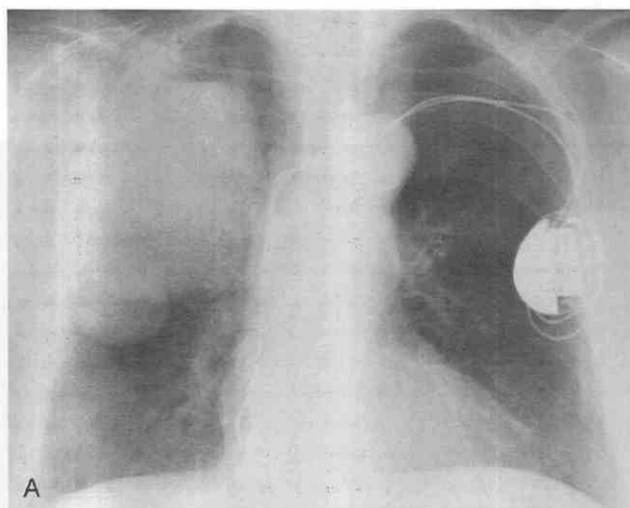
Large-cell lung cancer manifesting as a large cavitory mass. *A*, Posteroanterior chest radiograph shows a large, lobular mass in the right upper lobe. Cavitation is present with an air-fluid level in the upper aspect of mass. *B*, CT shows a well-circumscribed mass with eccentric cavitation and thick walls. Note the nonenlarged, paratracheal and low left paratracheal lymph nodes (*arrowheads*).
